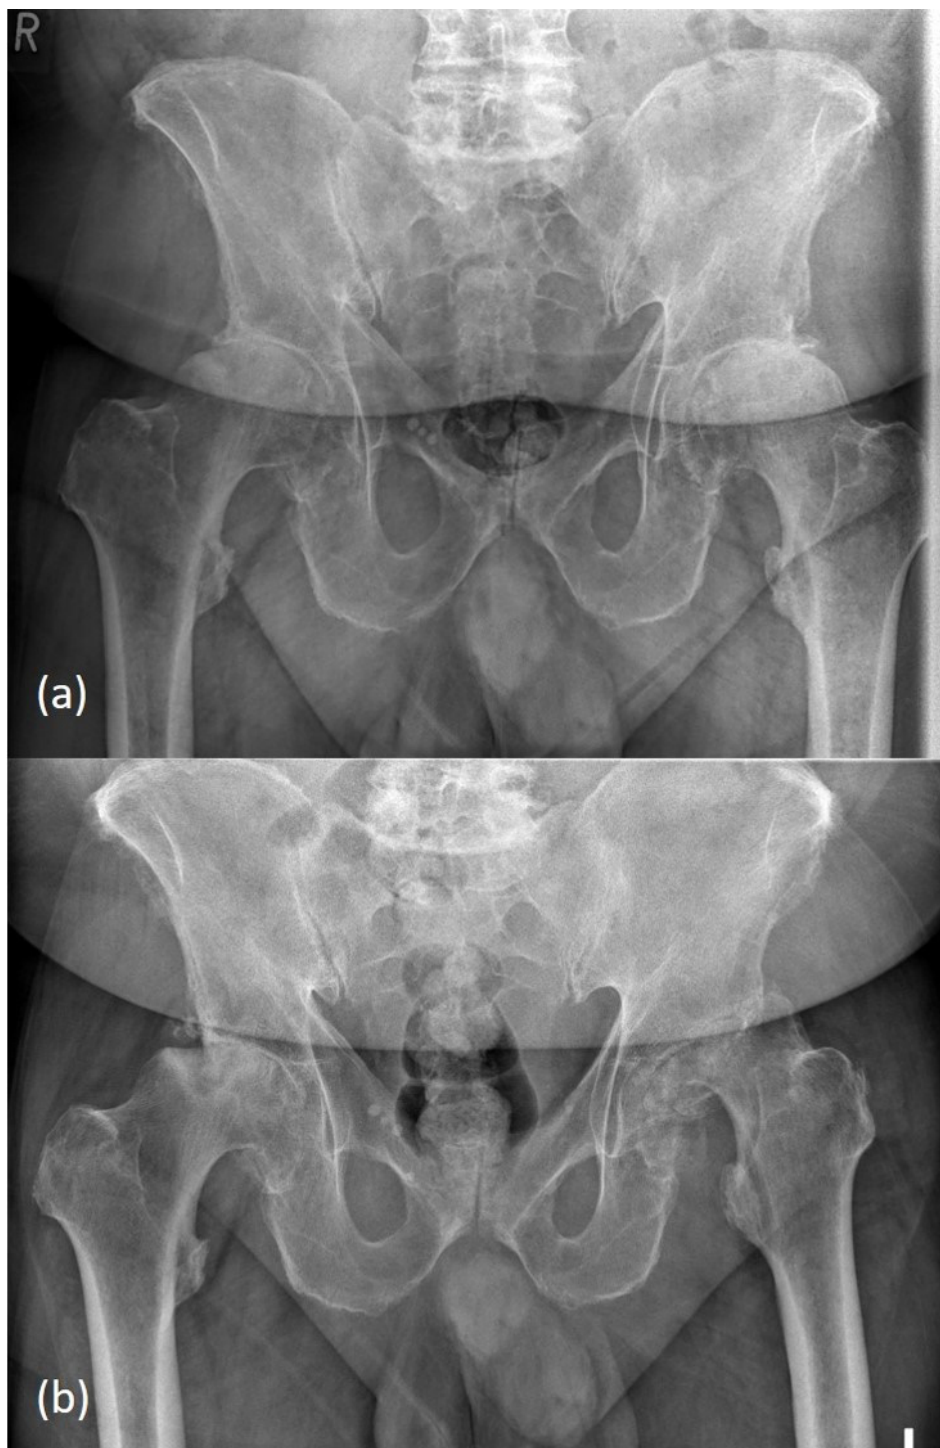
Copyright is held by the Regensburg University Medical Center. (a) X-ray of the pelvis showing advanced osteoarthritis of both hip joints. (b) X-ray of the pelvis showing femoral head necrosis on both sides with extensive osteolysis of both femoral heads and bone loss of the acetabular rim on the left side.
